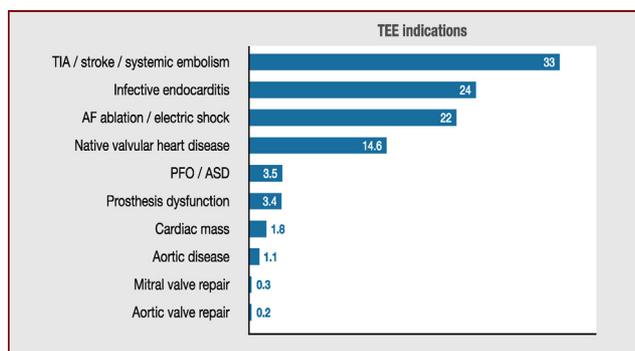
Transoesophageal echocardiography (TOE) indications. Data are expressed as percentages. AF: atrial fibrillation; ASD: atrial septal defect; PFO: patent foramen ovale; TIA: transient ischaemic attack.
